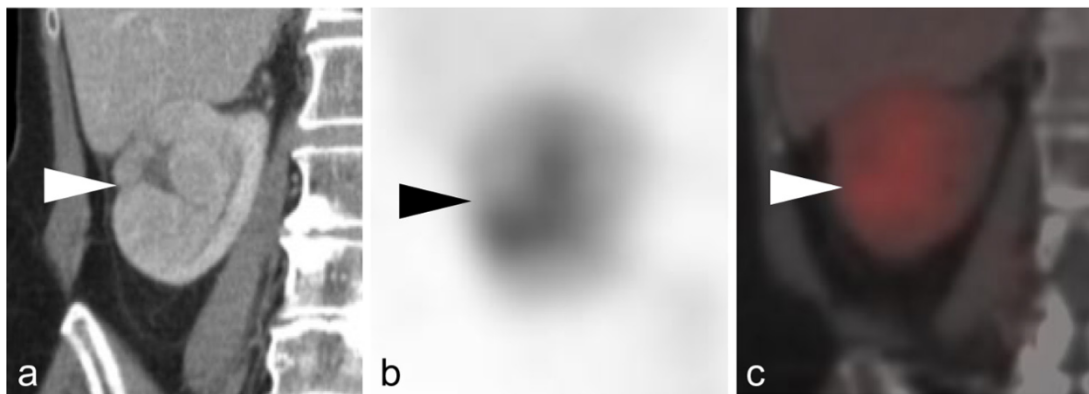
(a) Coronal venous/nephrographic phase contrast-enhanced CT, (b) coronal ^{99m}Tc -sestamibi SPECT, and (c) coronal ^{99m}Tc -sestamibi SPECT/CT fusion images of a large renal mass (white and black arrowheads) with a stellate central scar. This pathology proven oncocytoma demonstrates the typical pattern seen in the context of the presence of a central scar, with predominantly peripheral radiotracer uptake and relative photopenia in the scar.
